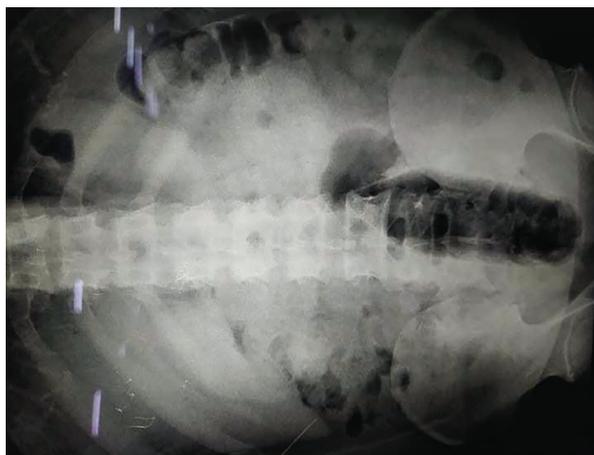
Abdominal X-ray suggestive of a conical foreign body in the rectum with air within.
